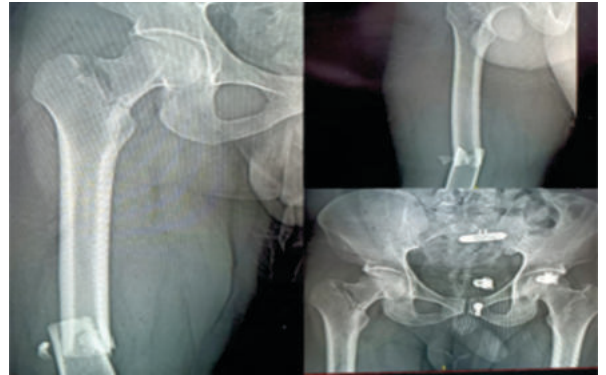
pre-operative Xrays
